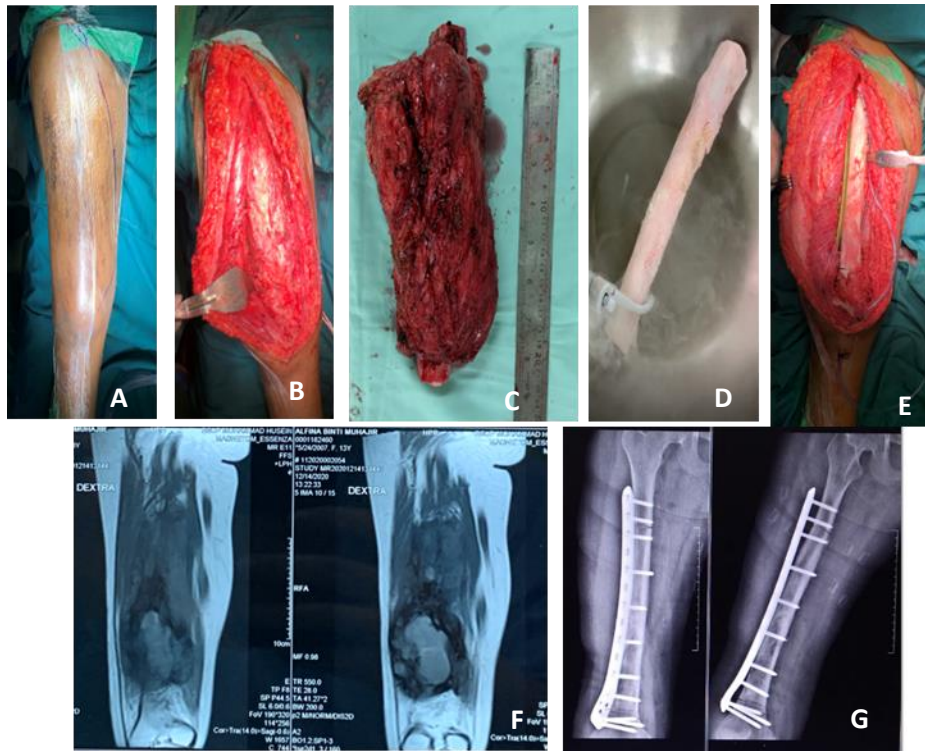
A clinical photo of a 13-year-old female with osteosarcoma involving the mid-shaft of the femur. B Intraoperative view of the tumor. C. Post-resection of the tumor. D. Post-submersion in liquid nitrogen. E. Post internal fixation. F. CT-imaging of preoperative state. G. X-ray imaging post internal fixation
